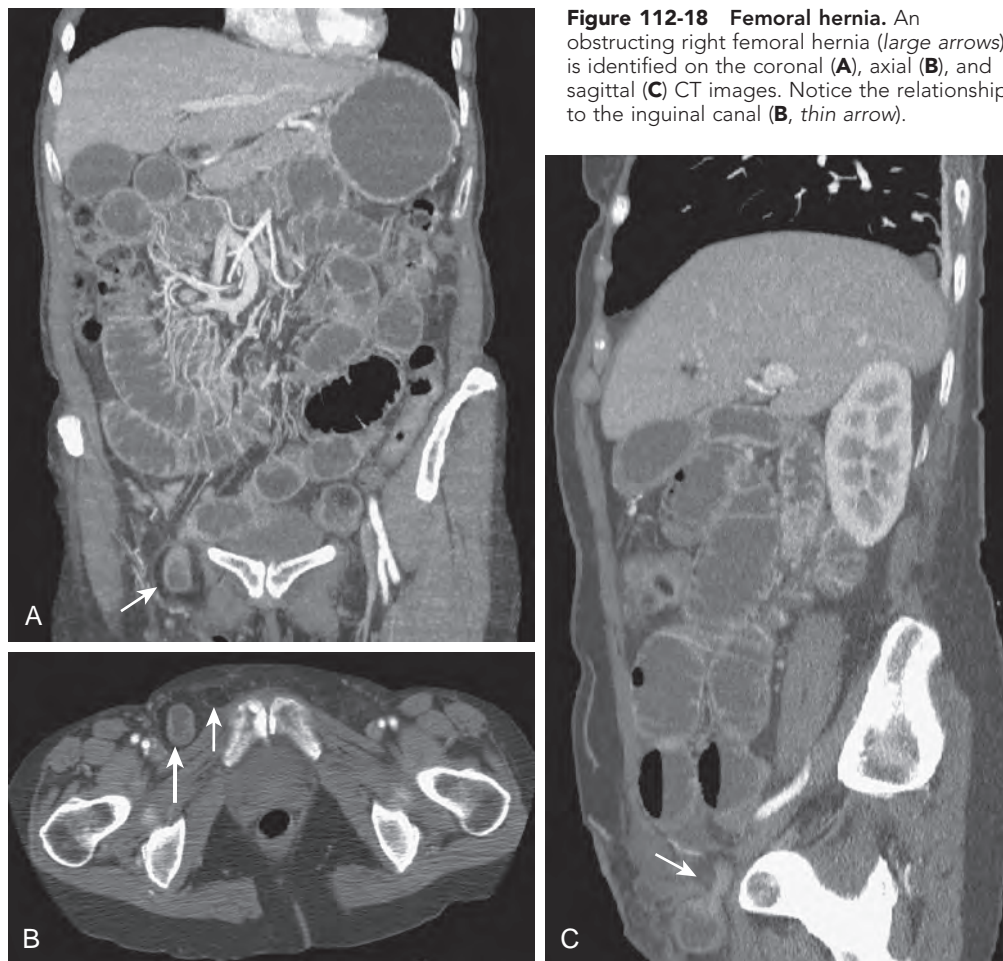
Femoral hernia. An obstructing right femoral hernia (large arrows) is identified on the coronal (A), axial (B), and sagittal (C) CT images. Notice the relationship to the inguinal canal (B, thin arrow).
